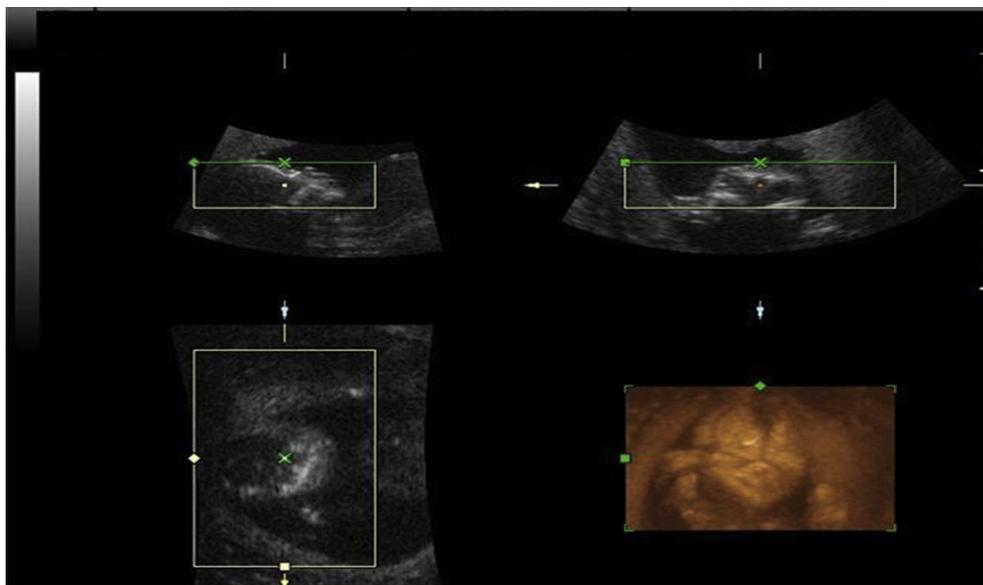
The fetal nasal bone is measured by three-dimensional ultrasound using both the surface and max modes. A rendering box over a normal surface is viewed from the ventral direction. The bottom-right panel reveals both nasal bones.
